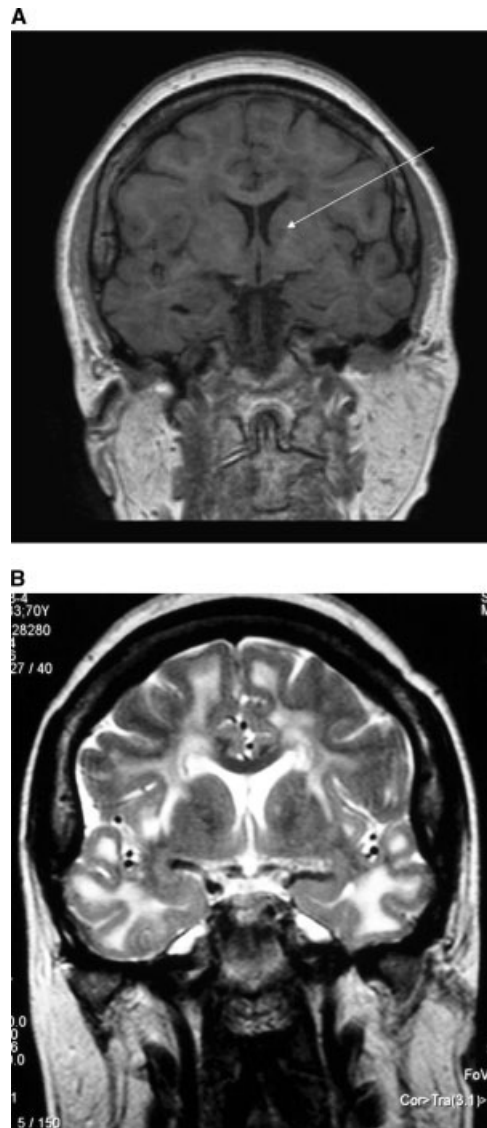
Coronal T1 magnetic resonance imaging (MRI) scan of the brain showing an infarct involving the left caudate nucleus in the proband (arrow), and coronal T2 MRI scan showing extensive white matter lesions involving periventricular areas, the anterior part of both temporal lobes, and the external capsule.
